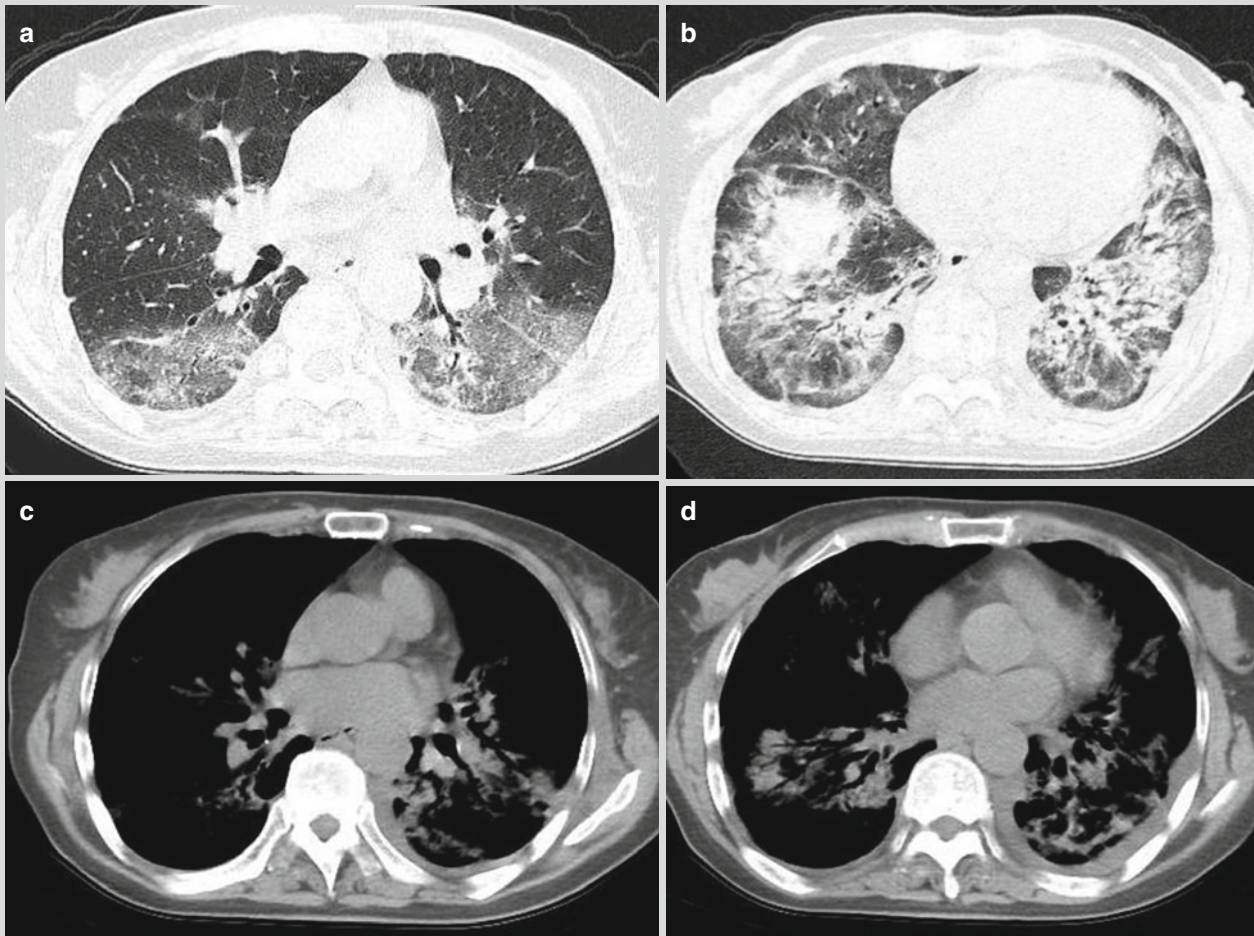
Legionella* pneumonia. (a–b) HRCT demonstrates multiple flakes of ground-glass opacities and consolidation shadows in both lungs, with internal air bronchogram sign. (c–d) Mediastinal window demonstrates both lung consolidation and a small quantity of arc-shaped liquid density shadows in both thoracic cavities. (e–f)
